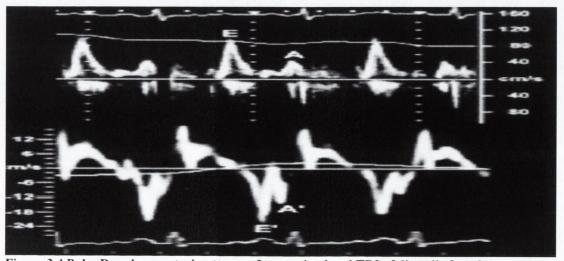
Pulse Doppler spectral patterns of transmitral and TDI of diastolic function
